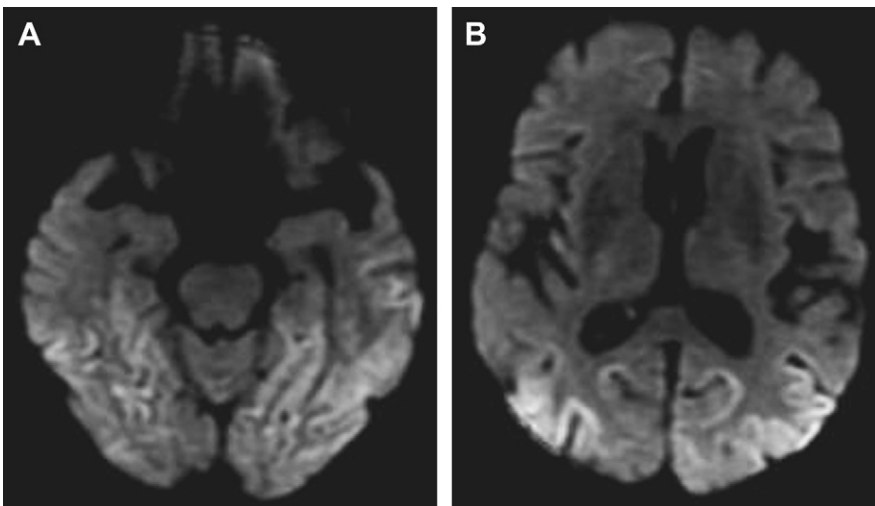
The Heidenhain variant of Creutzfeldt-Jakob disease. This woman's presenting complaint was deterioration of vision. Dementia followed later. This pair of diffusion-weighted images shows striking, bilaterally symmetric, cortical hyperintensities involving most of the occipital cortex and the temporal cortex. These lesions were also clearly visible on fluid-attenuated inversion recovery images (not shown) but very inconspicuous on T2-weighted image (not shown), partially because of their proximity to and the masking effect of very bright cerebrospinal fluid in the adjacent sulci. Note that the basal ganglia and thalami are normal.
